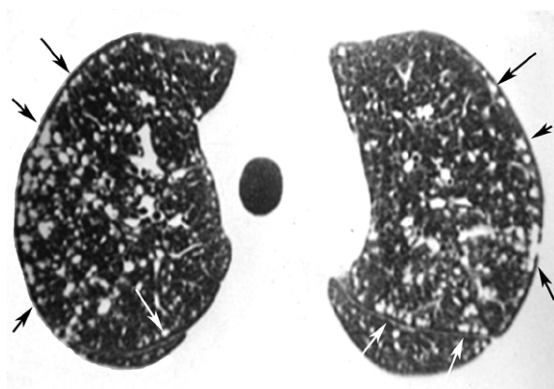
Axial CT scan at the level of the upper lobes, showing small soft-tissue density nodules that are distributed homogeneously throughout the lungs but do not touch the peripheral pleural surfaces (black arrows) or fissures (white arrows).
